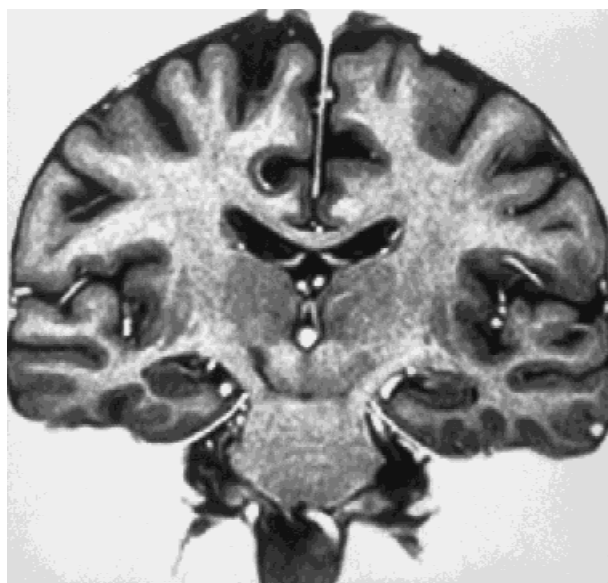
Magnetic Resonance Imaging (4.1 Teslas) of the brain (coronal view) from a patient operated 11 months earlier. A lesion of about two-thirds of the right subthalamic nucleus is seen. The dorsolateral region is mainly affected by the lesion, which also extends dorsally above the nucleus.
